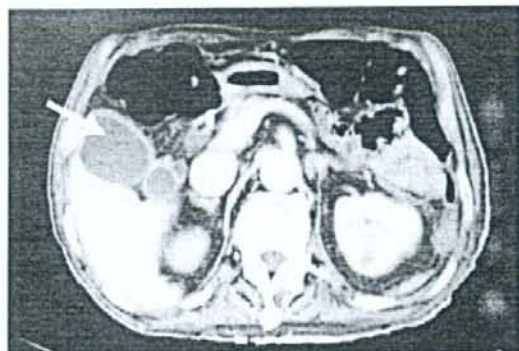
Case 1: Abdominal CT scan 2 months after the injury. A swollen gallbladder due to cholecystitis was observed (arrow).
